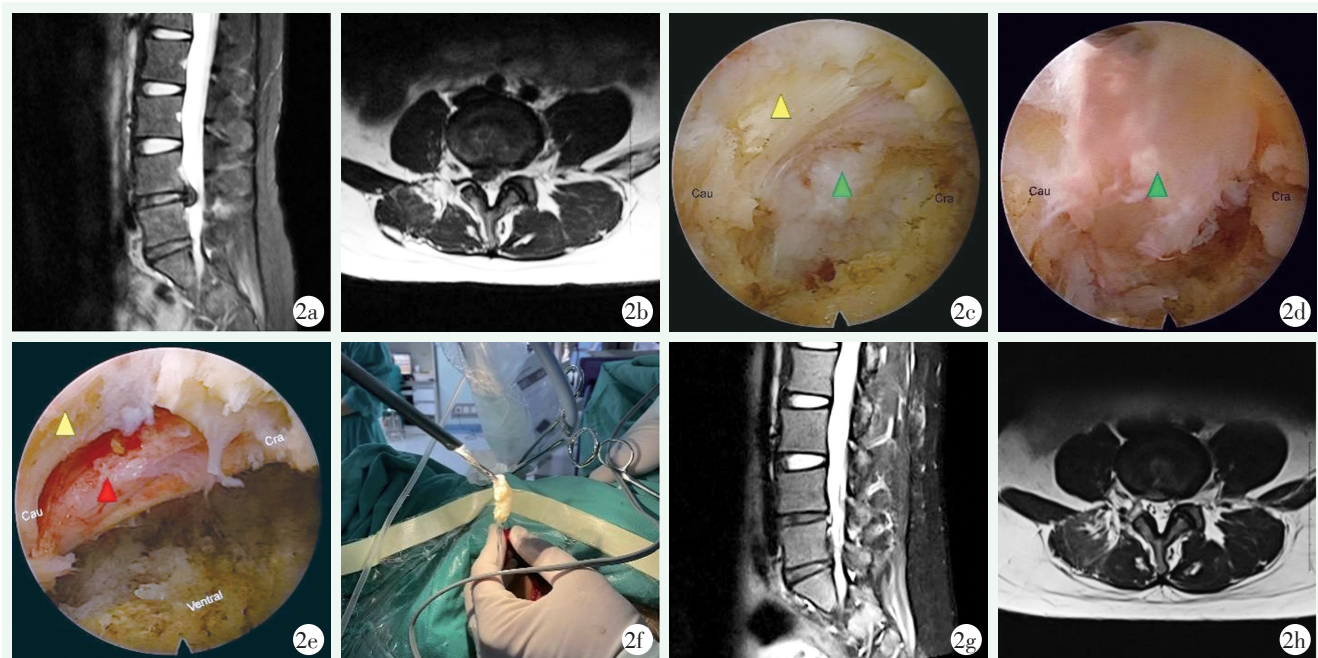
患者女性, 27 岁, 右侧 $L_{4/5}$ LDH。2a, 2b: 术前腰椎 MRI 示 $L_{4/5}$ 椎间盘右侧突出, 并挤压右侧 L_5 神经根及硬膜囊; 2c: PTED 术中内镜下见右侧 L_5 神经根受压; 2d: 术中内镜下髓核钳取出突出髓核组织; 2e: 术中内镜下见突出髓核摘除后神经根松弛, 表面血运恢复; 2f: 术中内镜下取出脱出髓核的外观; 2g, 2h: 术后腰椎 MRI 示硬膜囊形态基本恢复, L_5 神经根无受压。
